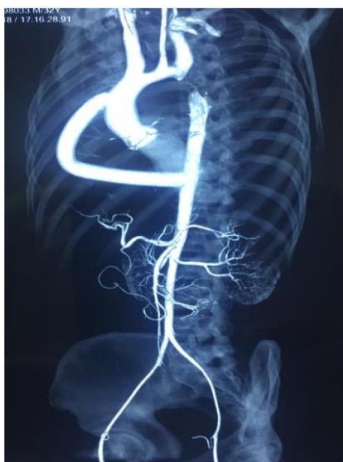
Postoperative, contrast-enhanced, 2-dimensional, computed tomography maximum intensity projection images shows patent flow in the 18 mm PTFE graft anastomosed end-to-side to the mid-portion of the ascending aorta and to the distal portion of the descending thoracic aorta. There is no luminal narrowing or filling defect. The collaterals disappeared within a month postoperatively.
